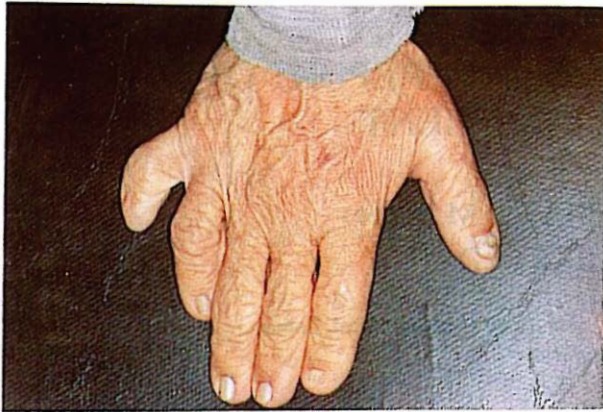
Radiography of the hand shows six fingers and hypoplastic nails.
